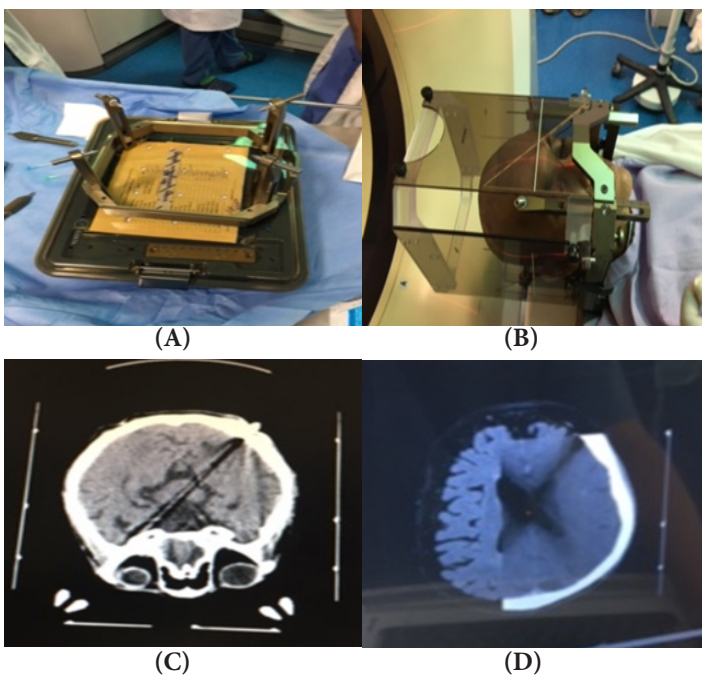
PLANNING: The Leskel Frame used in the case [A], the CT marking cage placed after the frame is fixed into the scalp for planning the trajectory of the probes [B], The planning CT scan in [C] which is merged with the MRI of the same patient at the same level to plan the coordinates [D]
